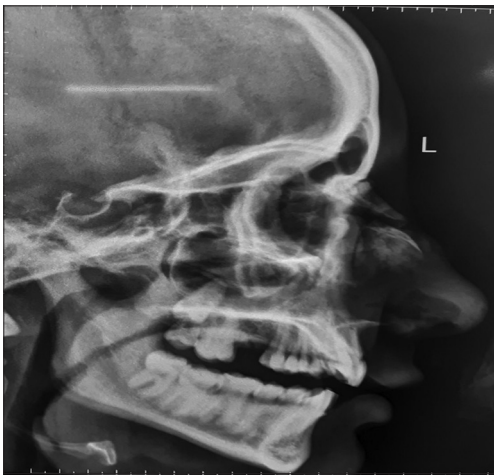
X-ray showing nasal bone fracture
